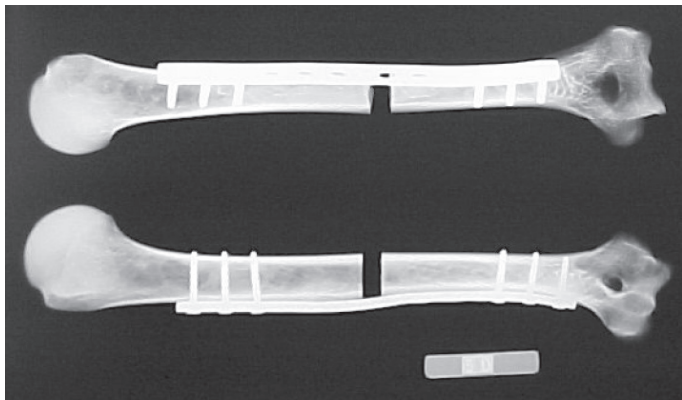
X-ray image of the DCP bridge plate assembly
